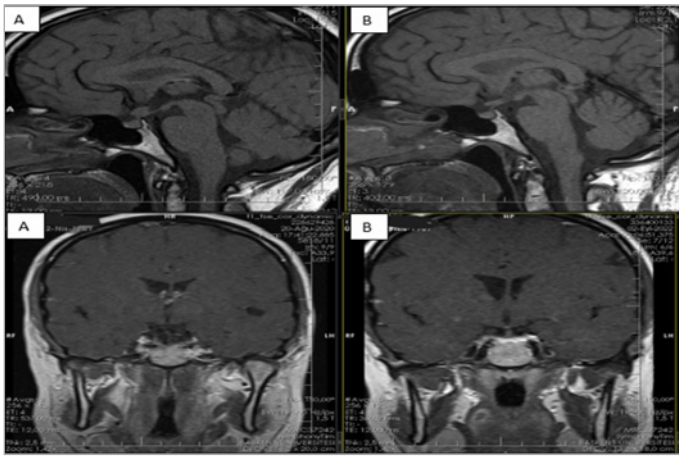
Pituitary MR image.
